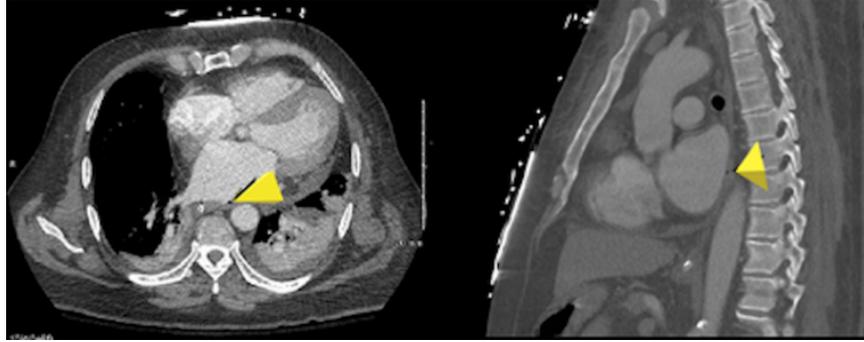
CT imaging. Multiple air bubbles seen between the esophagus and the posterior aspect of the left atrium, concerning for atrio-esophageal fistula (arrow in left frame). This is also associated with small pseudoaneurysm along the posterior wall of the left atrium (arrow in right frame).
